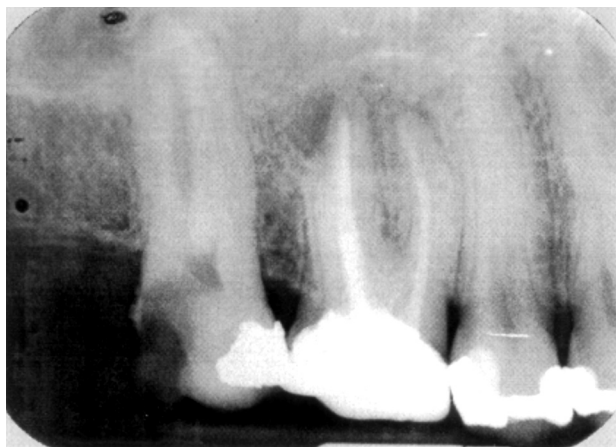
Radiograph of a patient with periapical lesion.
